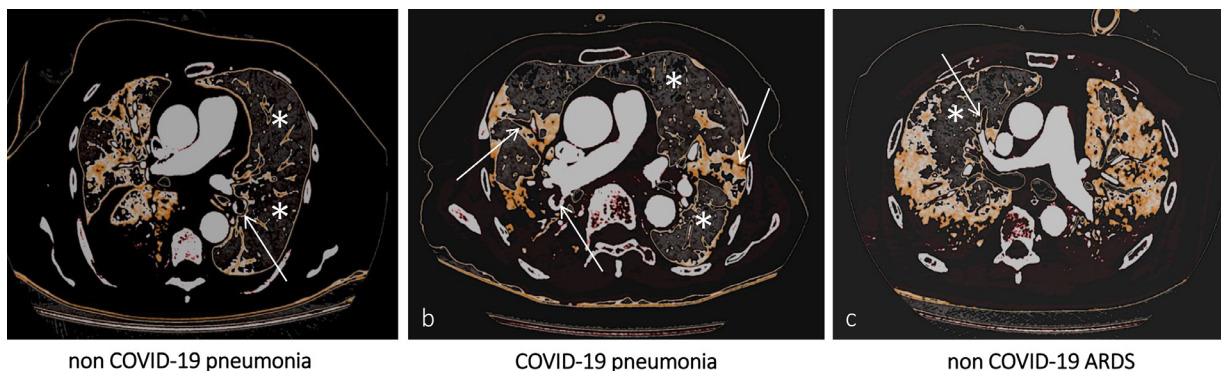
Central image/visual abstract: Computed tomography pulmonary angiography (CTPA) imaging demonstrating, in three different clinical scenarios, eventual filling defects in branches of the pulmonary arteries (white arrows) and their spatial distribution according to the corresponding ventilation maps (white asterisks indicate normal lung parenchyma). In (A) (non-COVID-19 pneumonia) and (C) (non-COVID-19 ARDS) filling defects are electively found in the branches of the pulmonary arteries, accountable for the vascularization of healthy lung segments. On the contrary, in (B) (COVID-19 pneumonia), there is an almost perfect topographical overlap between filling defects distribution and pneumonia extent. COVID-19, coronavirus disease 2019.
